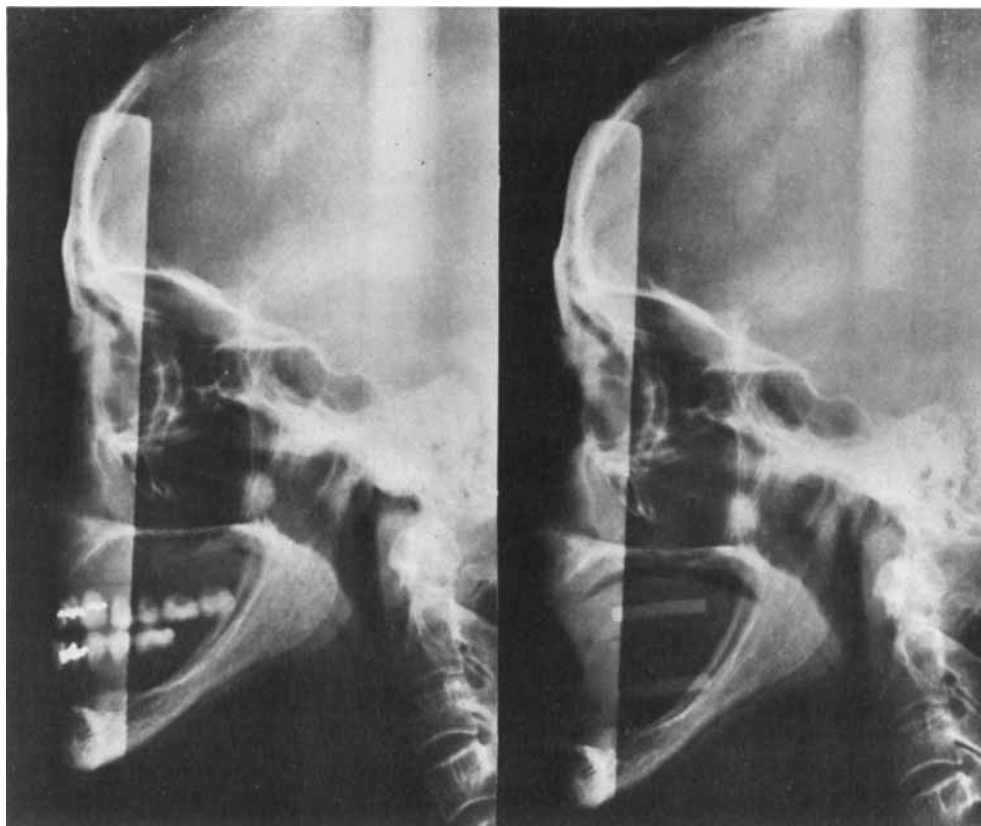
Profile radiographs with the old (*left*) and new dentures (*right*) in occlusion. The new dentures increased the vertical dimension by 6 mm.
